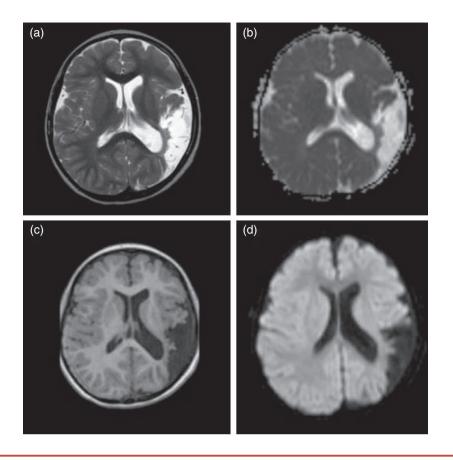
Follow-up imaging 3 years after arterial ischemic stroke (AIS) of a male who presented at 13 months with right sided hemiparesis. Axial T2weighted imaging (a), apparent diffusion coefficient maps (b), T1-weighted imaging (c), and diffusion-weighted imaging (d) demonstrate the absence of diffusion restriction (i.e. absence of acute cytotoxic oedema) and the longstanding encephalomalacic changes typical of the chronic phase of the infarction.
